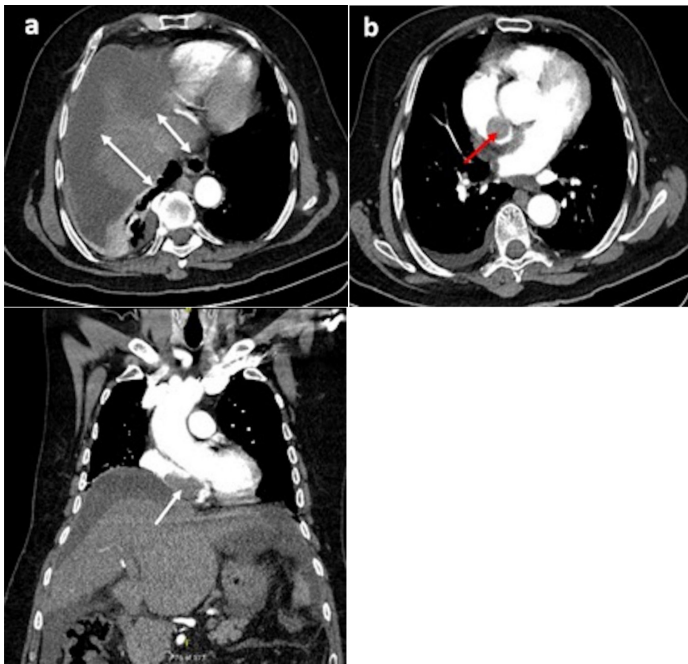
CTA demonstrating findings: a Intra-hepatic mass (white arrow) with filling defects in a dilated IVC (white arrow). b Filling defects noted in the RA (red arrow). c. coronal view of filling defect in the IVC (white arrow)
